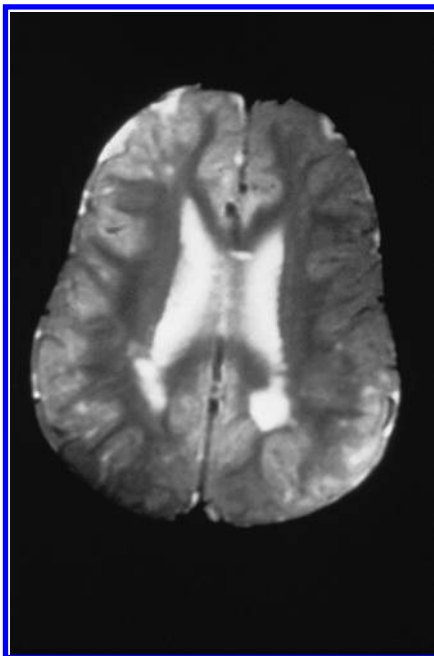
Magnetic resonance image of the brain of SR, a four-year-old patient with multiple sulfatase deficiency. Moderately extensive high T_2 changes in the subcortical white matter were present bilaterally.
